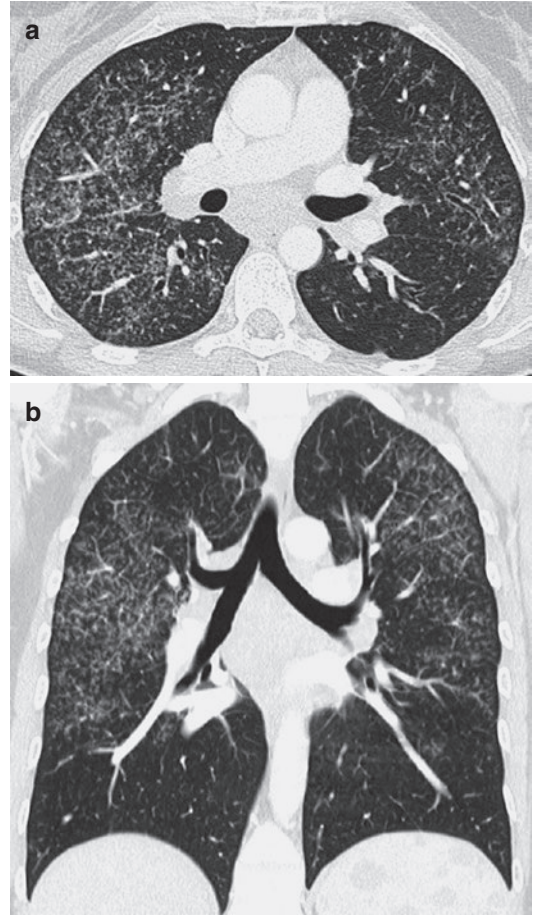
31-year-old woman with sarcoidosis. (a) Axial CT image shows multiple uniformly sized nodules as well as nodular thickening of the interlobular septa and the bronchial walls. (b) The upper lobe predominance of the nodules can be seen on the coronal CT image
